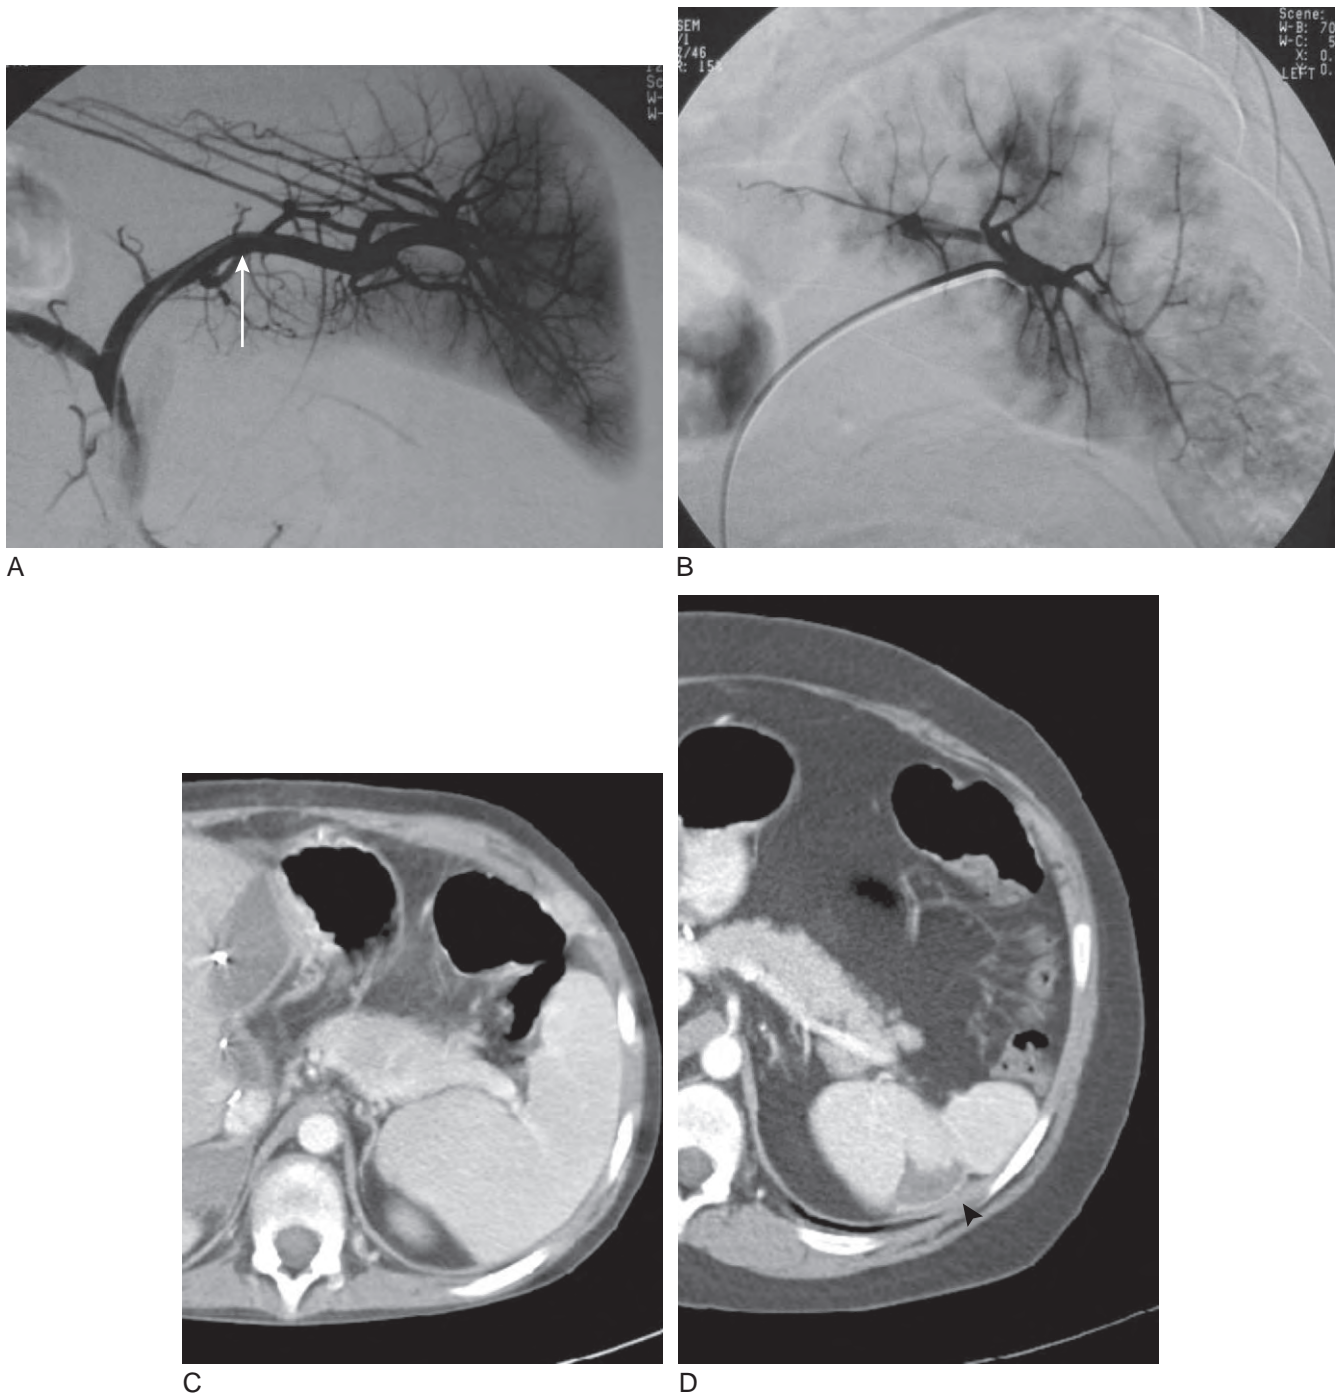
A, Normal splenic arteriogram (*arrow*) with parenchymal-phase enhancement in a 14-year-old with hypersplenism and thrombocytopenia after hepatic transplantation. (Courtesy of Dr. A. Arapally, Johns Hopkins Hospital.) B, Digital subtraction angiography of a splenic arteriogram after 70% embolization demonstrates a mottled enhancement pattern. C, Contrast-enhanced computed tomography (CT) scan before embolization. Note the size of the spleen. D, Contrast-enhanced CT scan 3 months after embolization. Note the decreased size of the spleen and small peripheral infarct (*arrowhead*).
